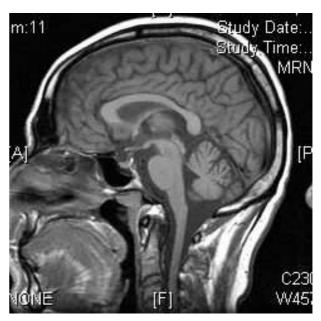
(B) Sagittal T1-weighted RM image of an alcoholic patient, with severe atrophy of corpus callosum (area=4.9542 mm²/mm).
